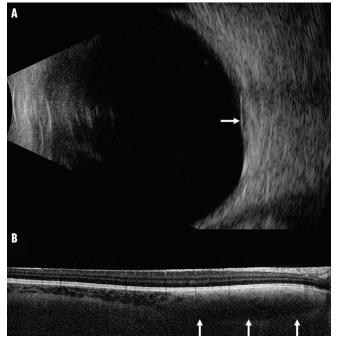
Ultrasonography of the right eye shows a flat, dense choroidal mass with thickness of 1.83 mm (arrow, A). OCT shows an intact retina with no subretinal fluid and the deep choroidal mass with loss of vascular markings (arrows, B).
